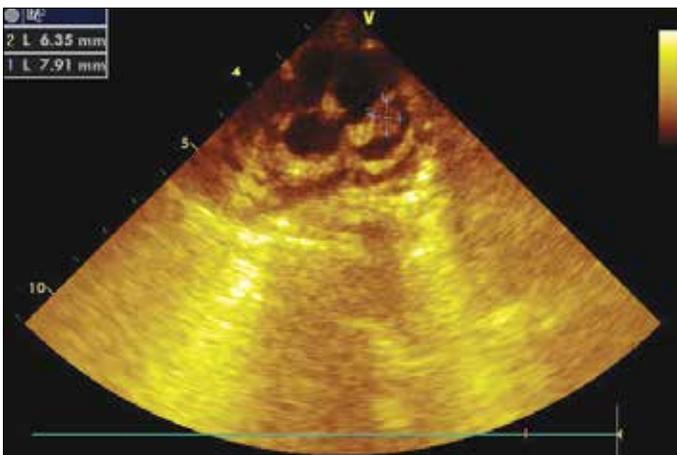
In the giant aneurysm 6.3x7.9 mm size thrombus was observed at parasternal short-axis view in echocardiography
